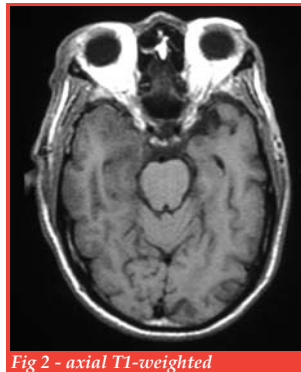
axial T1-weighted
